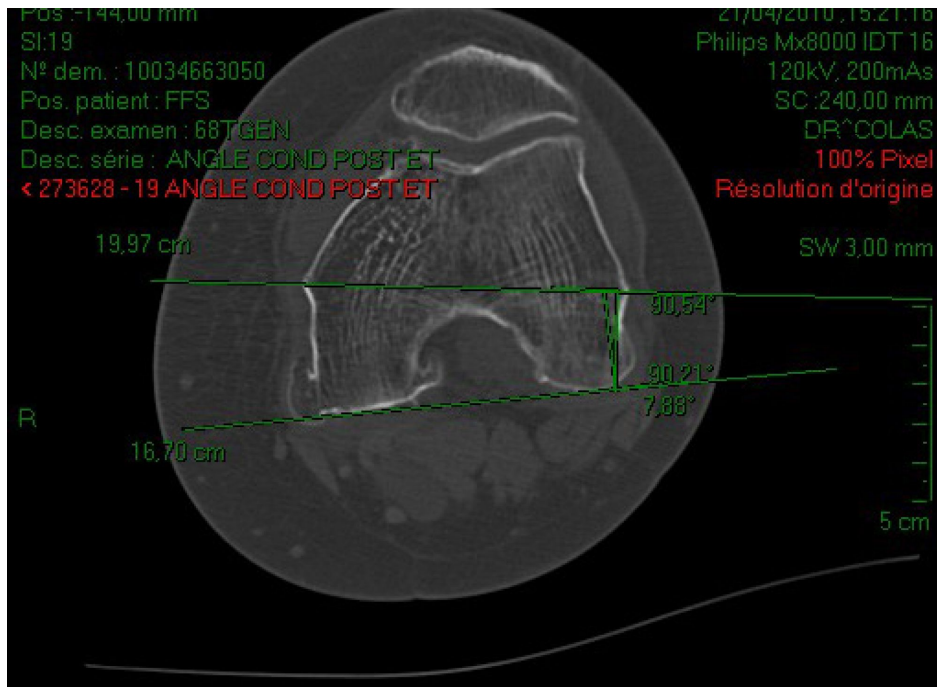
Preoperative CT of a knee to be replaced, calculating the angle between the posterior condylar plane and the axis that passes through the two epicondyles. Here it measures 8°.
